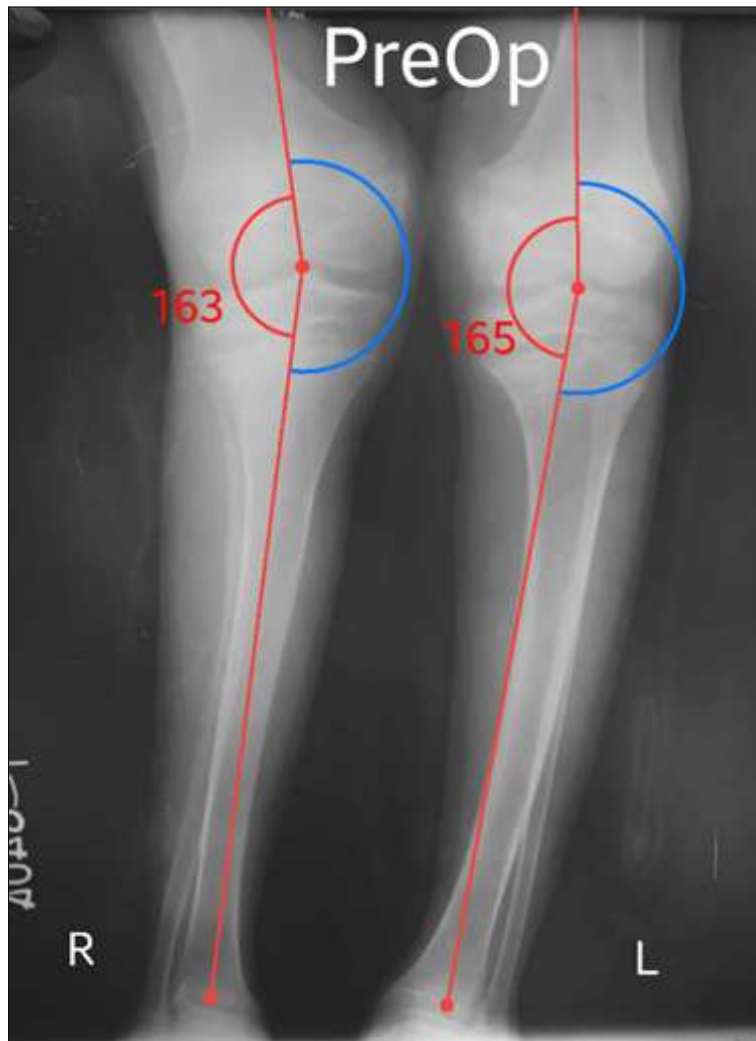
Preop AP Xray of both knee showing significant Windswept deformity (Right Genu Valgum & Left Genu Varum).
